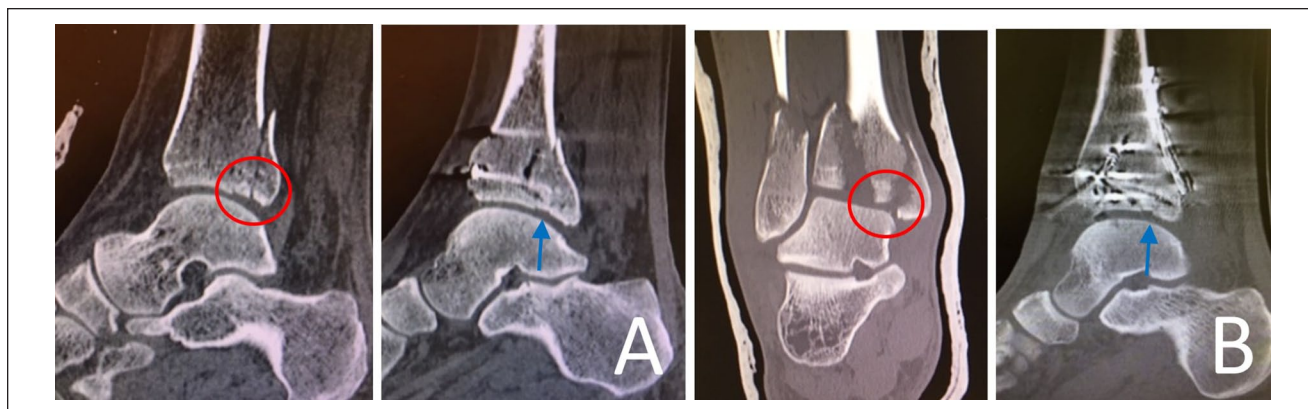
(A, B) Computed tomographic scan showing 2 patients with small intercalary fragments with mild impaction that we decided not to reduce to avoid resecting them.
